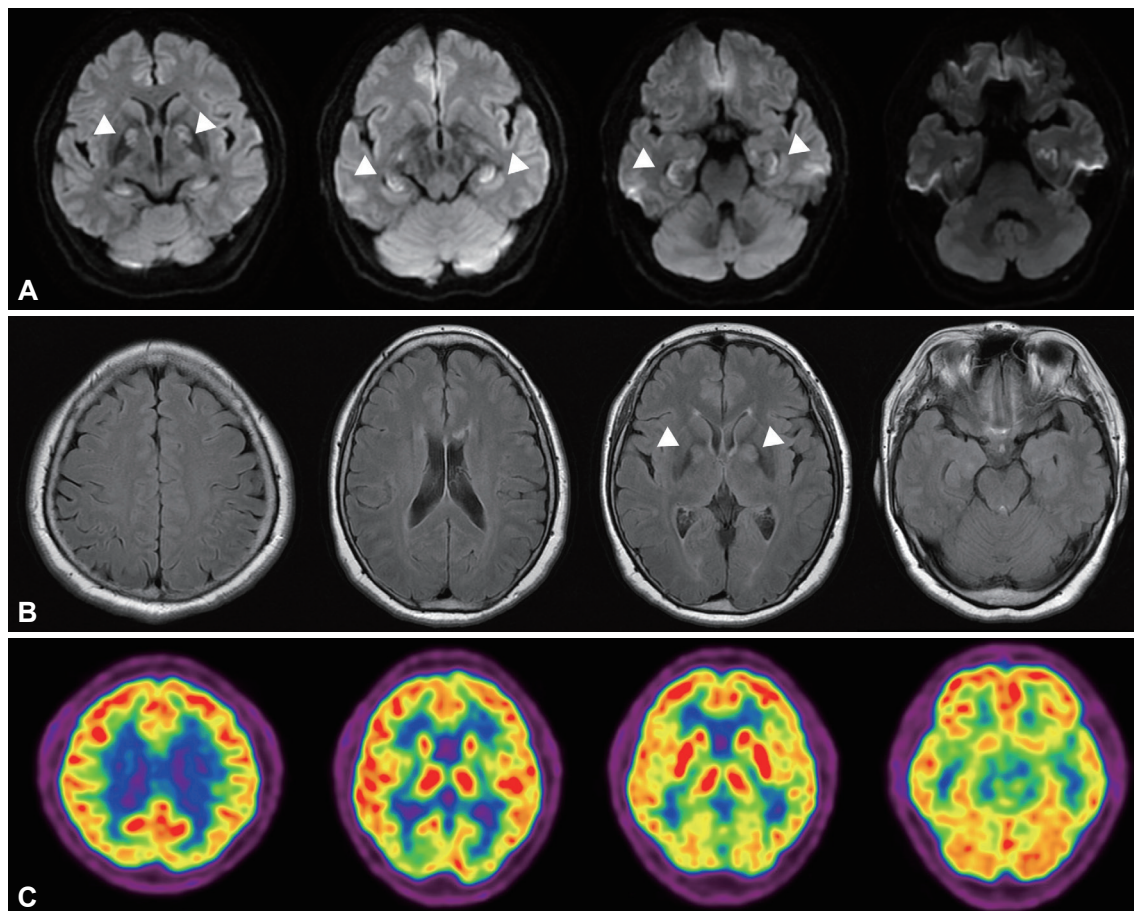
Radiological findings of the patient. A: Axial diffusion-weighted imaging showed diffusion restriction (arrowheads) bilaterally in the globus pallidus and hippocampus. B: Axial FLAIR imaging showed high signal intensities (arrowheads) bilaterally in the globus pallidus and hippocampus. C: FDG-PET showed diffuse cerebral decreases and slight reductions in basal ganglia glucose uptake. FDG-PET, fluorodeoxyglucose positron-emission tomography; FLAIR, fluid-attenuated inversion recovery.
